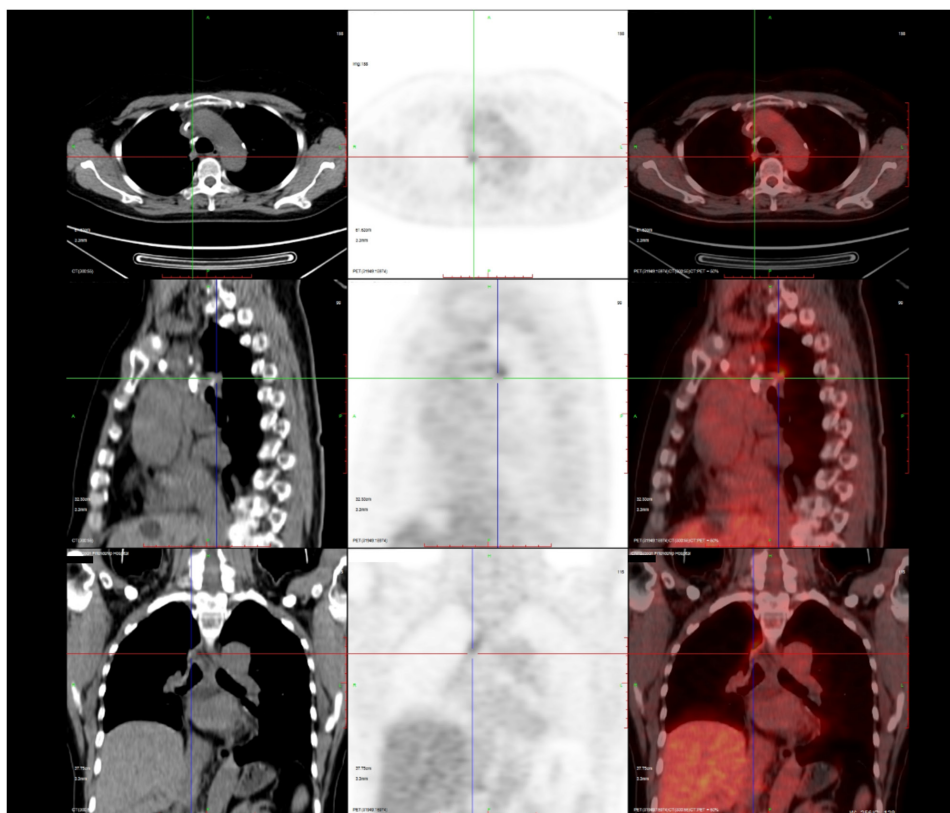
Patient's positron emission tomography-computed tomography scan results from October 2020, indicating recurrence.
